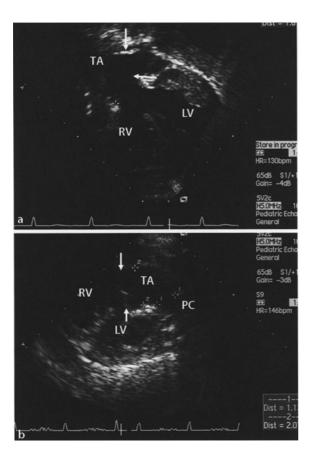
Truncus arteriosus: echocardiography. a Subxiphoid view showing the origin of the truncus arteriosus above a very large ventricular septal defect, and the origin of the pulmonary artery component (white arrows), b longaxis view in the same patient showing the origin of the truncus arteriosus with the truncal valve (white arrows), and the origin of the pulmonary artery component (*LV* left ventricle, *RV* right ventricle, *PC* pulmonary artery component, *TA* truncus arteriosus) (photographs courtesy of Dr. Stefano di Bernardo)
